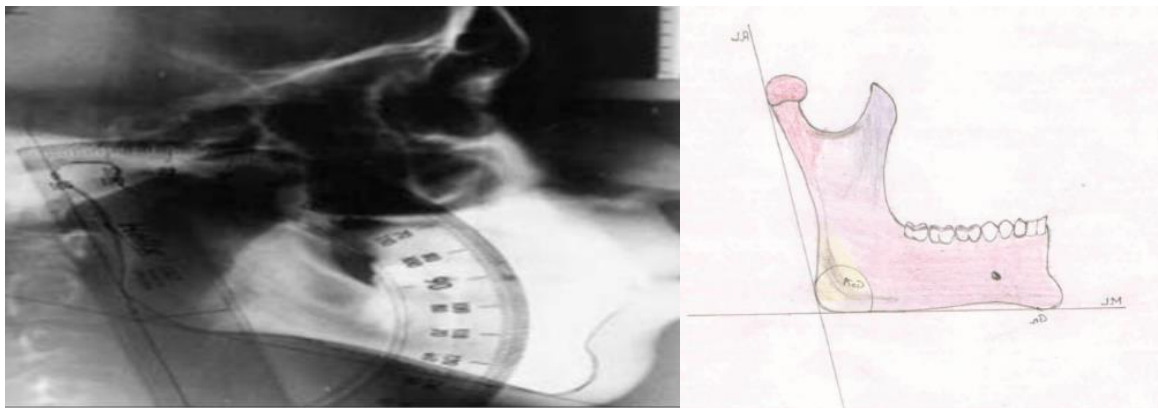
Radiographic methods used in the determination of gonial angles
